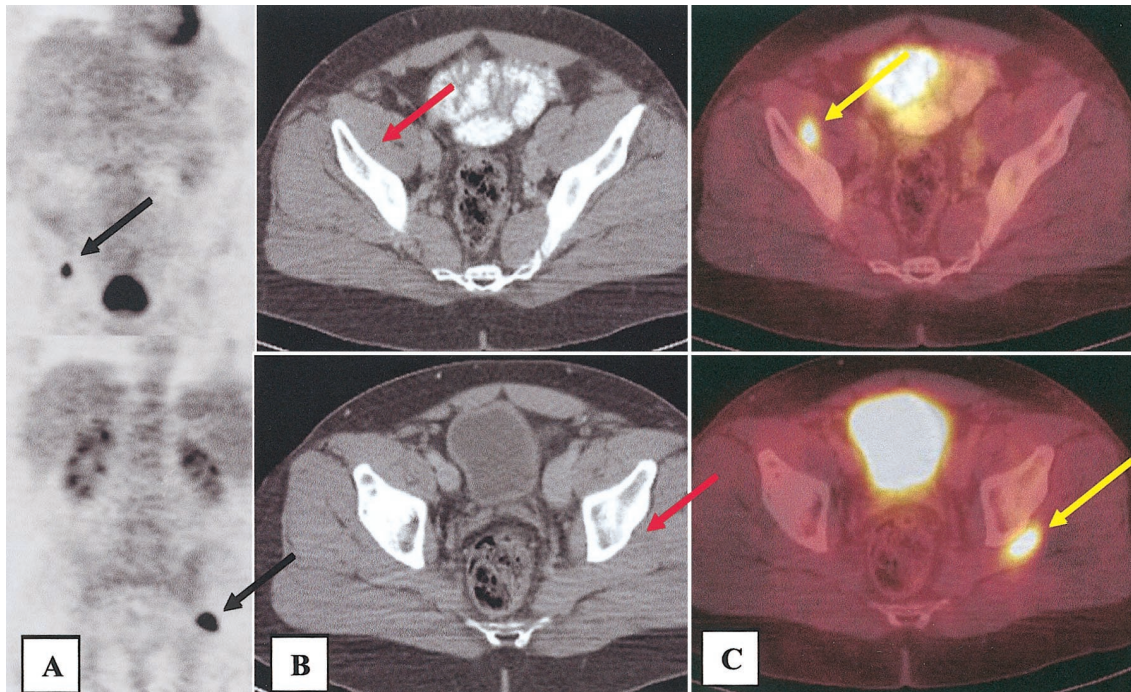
(A) Coronal PET. (B) Axial CT. (C) Axial PET/CT. Patient had a history of non-Hodgkin's lymphoma in remission and had recent complaints of pelvic pain. Coronal PET images demonstrate multiple foci of intense FDG uptake in the pelvic area initially thought to represent abnormal foci within the osseous structures. CT images do not demonstrate any abnormalities. PET/CT images localize lesions to soft tissue (yellow arrows) rather than bone.
